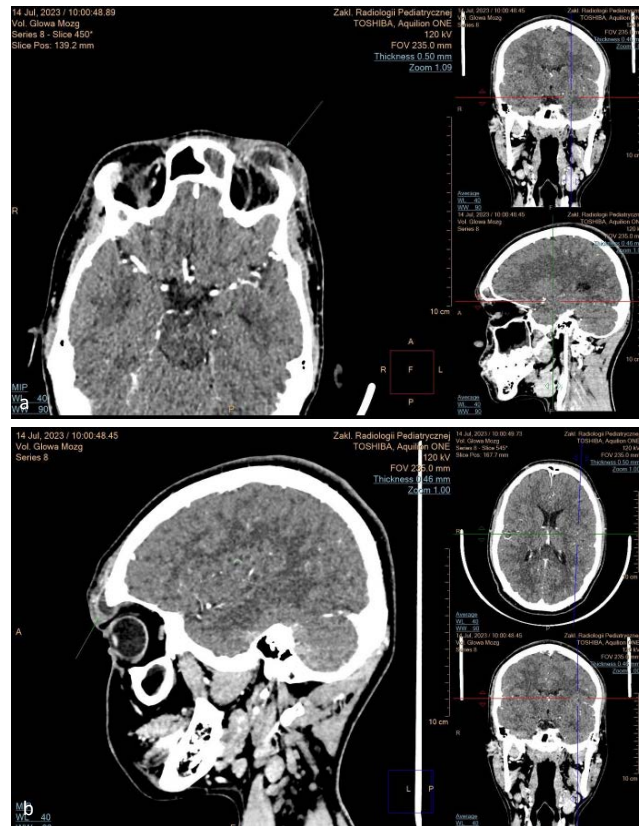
The second contrast-enhanced CT scan
